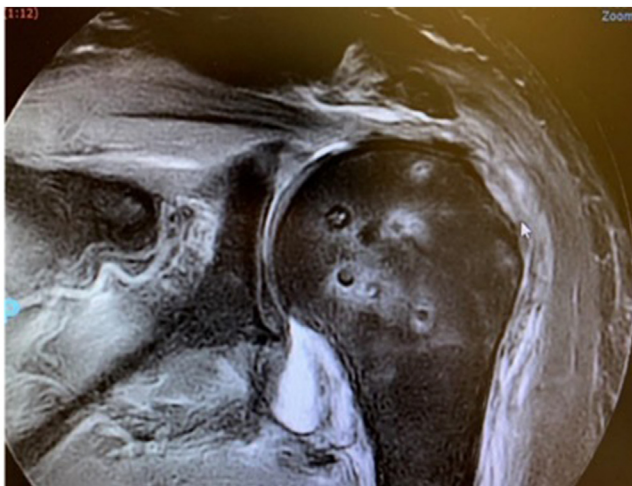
Postoperative T2-weighted coronal magnetic resonance imaging (MRI) showing intact cuff repair integrity.
